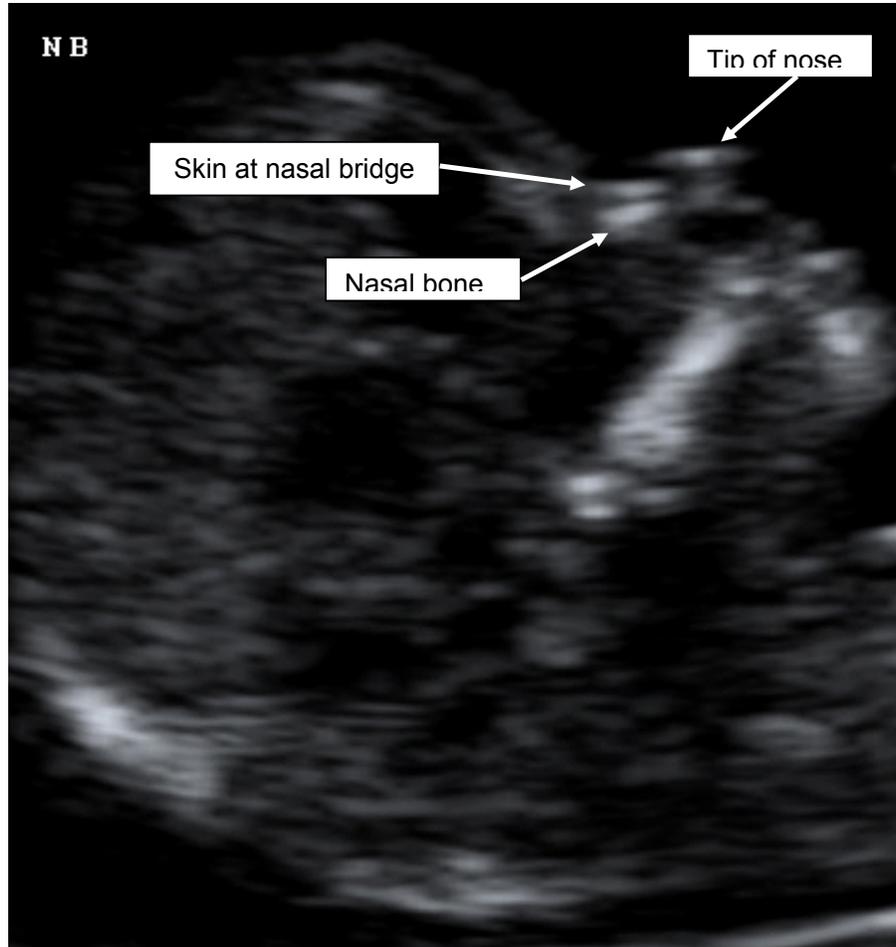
An ultrasound image showing a fetal head in the late first trimester, along with the identification of the nasal bone. In this midsagittal view, the “equal sign” is clearly visible, made up of the nasal bone (lower line) and the skin on the nose (upper line). The tip of the nose is also visible. These three landmarks indicate an appropriate view for detecting the presence (or absence) of the nasal bone (image courtesy of Dr. Alan Donnfeld).
